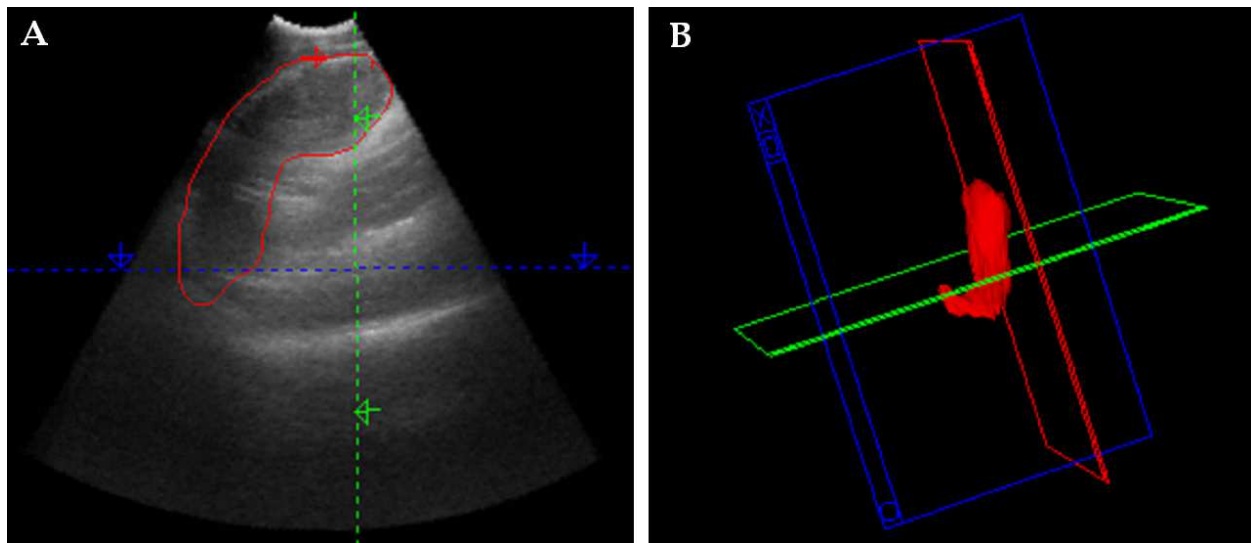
3D ultrasound to measure gastric emptying (A) a region of interest drawn around the stomach (B) reconstructed volumetric image of the stomach.
